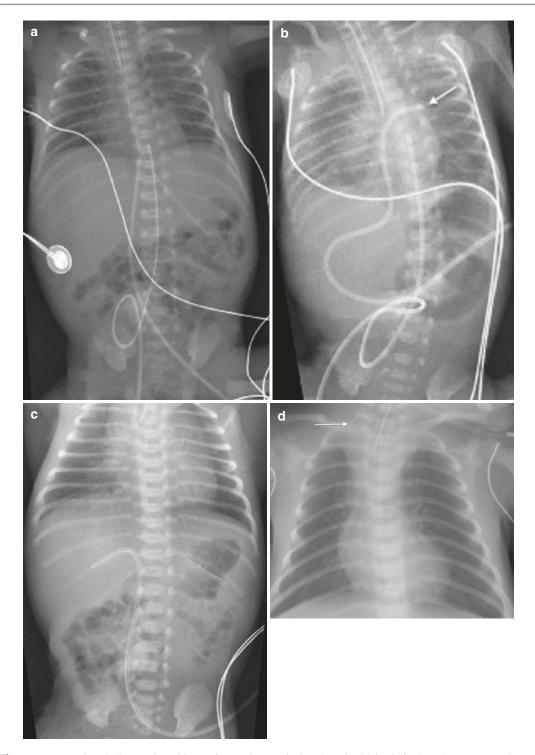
Normal and abnormal positions of vascular access lines. (a) Chest and abdominal radiograph shows normal positions of umbilical arterial catheter (UAC) and umbilical venous catheter (UVC). The endotracheal tube and nasogastric tube are also in a satisfactory position. (b)
